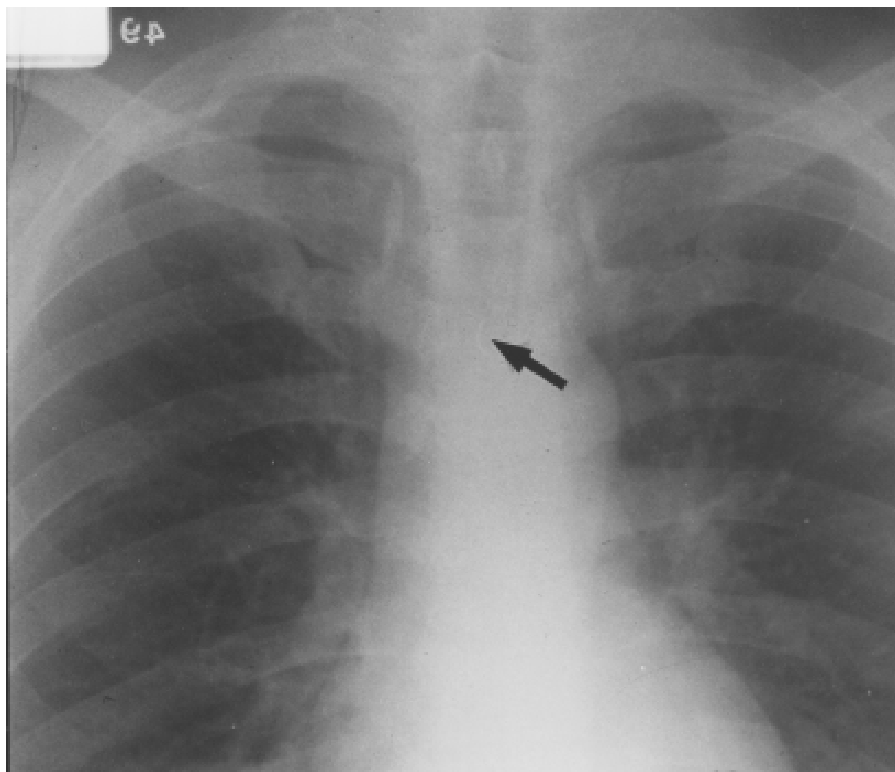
Chest X-ray showing metal spike in the upper esophagus.
